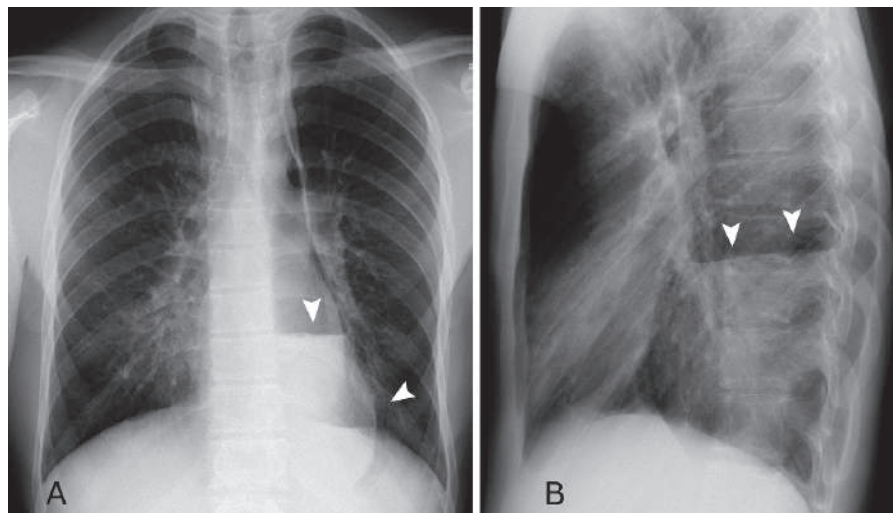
Posteroanterior (a) and lateral (b) plain chest radiographs in a patient with achalasia shows mild widening of the mediastinum and air fluid level behind the cardiac silhouette (arrowheads), representing fluid content within the dilated esophagus
